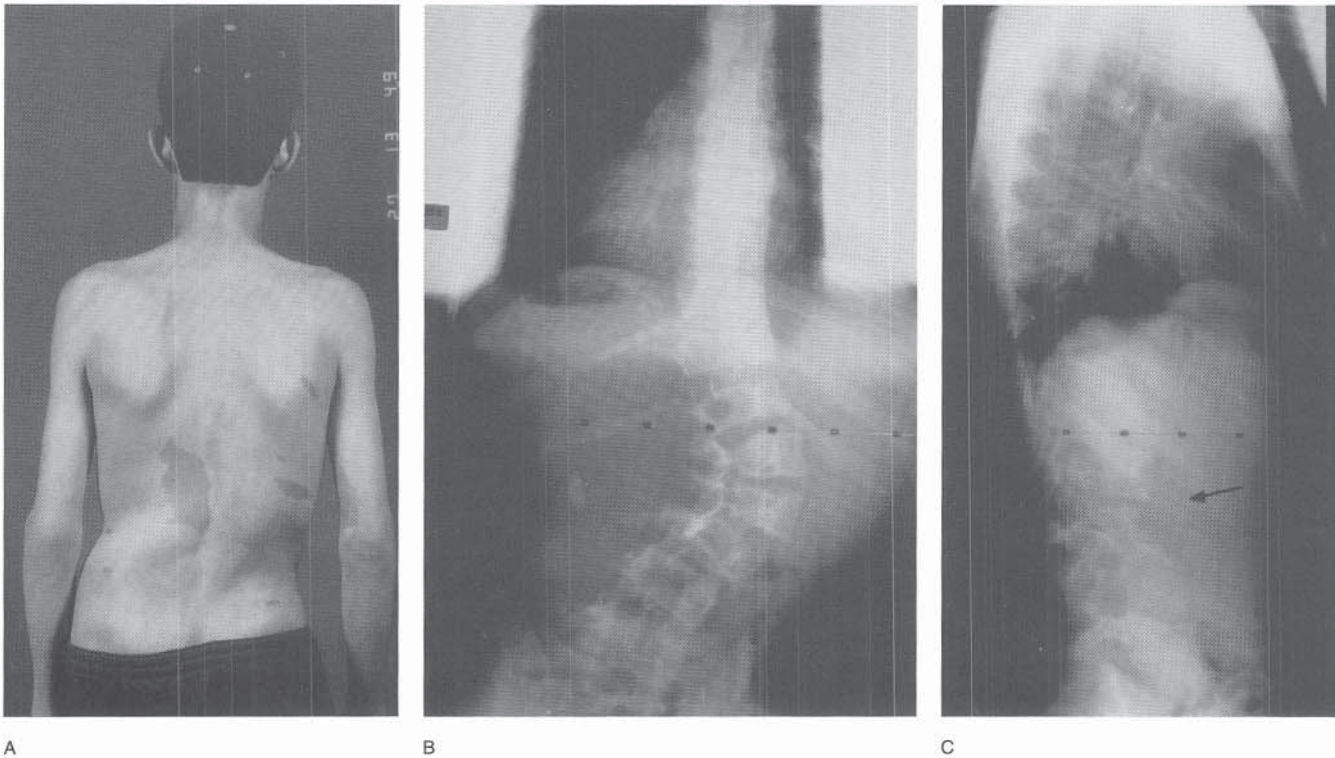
A, Clinical appearance of a 16-year-old male patient with neurofibromatosis and a thoracolumbar scoliosis with the convexity to the right. B and C, PA and lateral radiographs of the spine demonstrating the dystrophic nature of the curve, as evidenced by erosions of the vertebral bodies.
